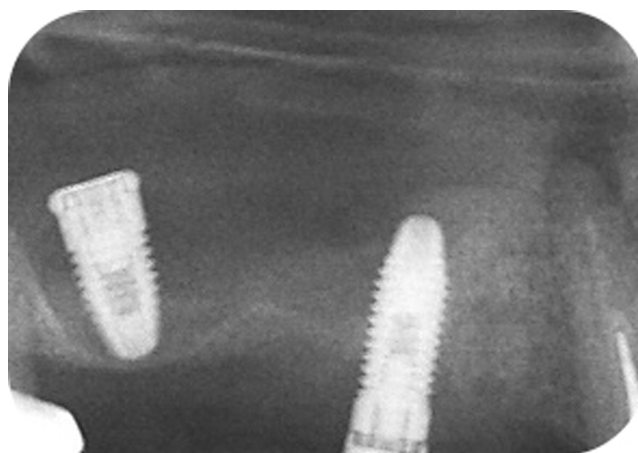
Panoramic radiograph showing a dental implant into the right side of the maxillary sinus.
